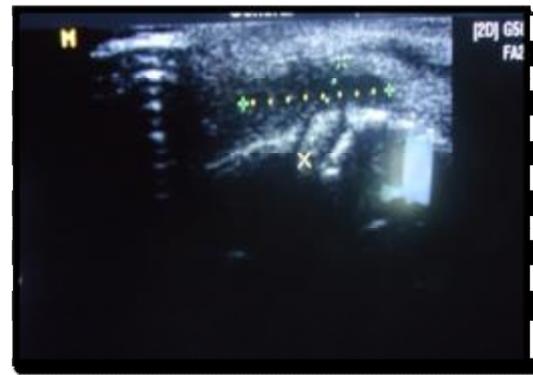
Ultrasound of periapical abscess show irregular margin and hypoechoic texture
